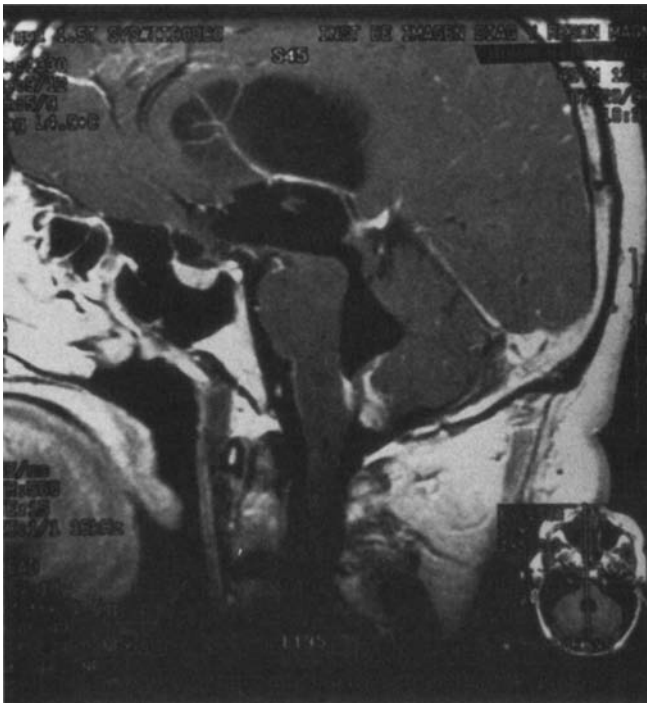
Sagittal T₁-weighted MRI with gadolinium shows intraventricular and subarachnoid active cysts in a 45-year-old man with increased intracranial pressure, meningeal signs, and hydrocephalus.
